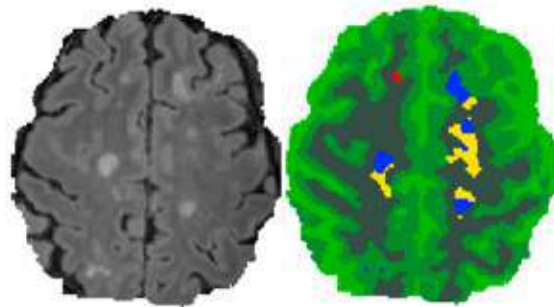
Example of a skull-stripped FLAIR image and the resulting segmentation (green: healthy tissues; blue: T_1 black holes; red: $T_{1\text{contrast}}$ acute lesions; yellow: T_2 lesions)
